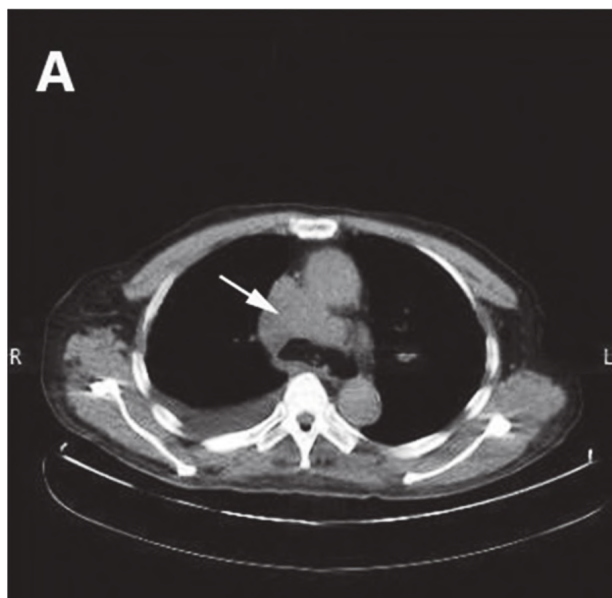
Contrast-enhanced chest CT scan demonstrating multiple, enlarged lymph nodes in the (A) pretracheal (arrow), (B) prevertebral (arrow), and (C) subcarinal (arrow) regions.
